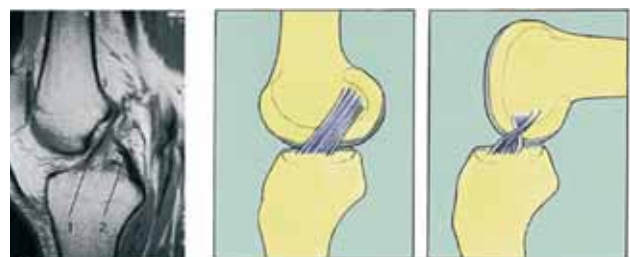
Anterior cruciate ligament (ACL): Left: MRI of normal ACL (1) and PCL (2). Middle: ACL in extension. Right: ACL in flexion
